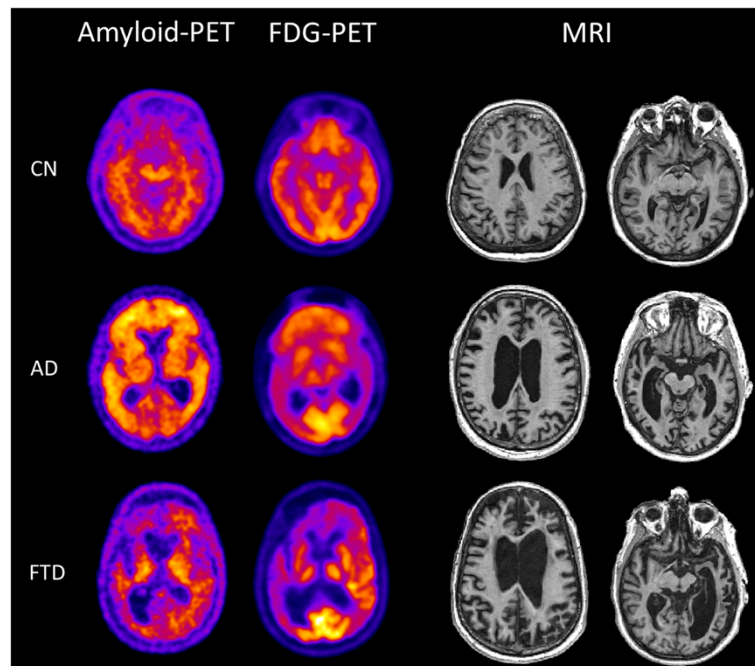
Amyloid imaging of Alzheimer's disease and frontotemporal dementia. Typical amyloid positron emission tomography (Pittsburgh Compound B-PET), fluorodeoxyglucose (FDG)-PET and magnetic resonance imaging (MRI) images seen in a cognitively normal individual (CN), an Alzheimer's disease (AD) patient and a frontotemporal dementia (FTD) patient. The CN individual shows no evidence of amyloid deposition, normal metabolic uptake and normal structural MRI scan. The AD patient shows significant amyloid uptake throughout the brain, significant low parietal lobe FDG uptake and significant ventricular expansion on the MRI scan. The FTD patient shows no significant amyloid deposition, significant frontal and temporal lobe deficits and atrophy, which are both highly asymmetric.
